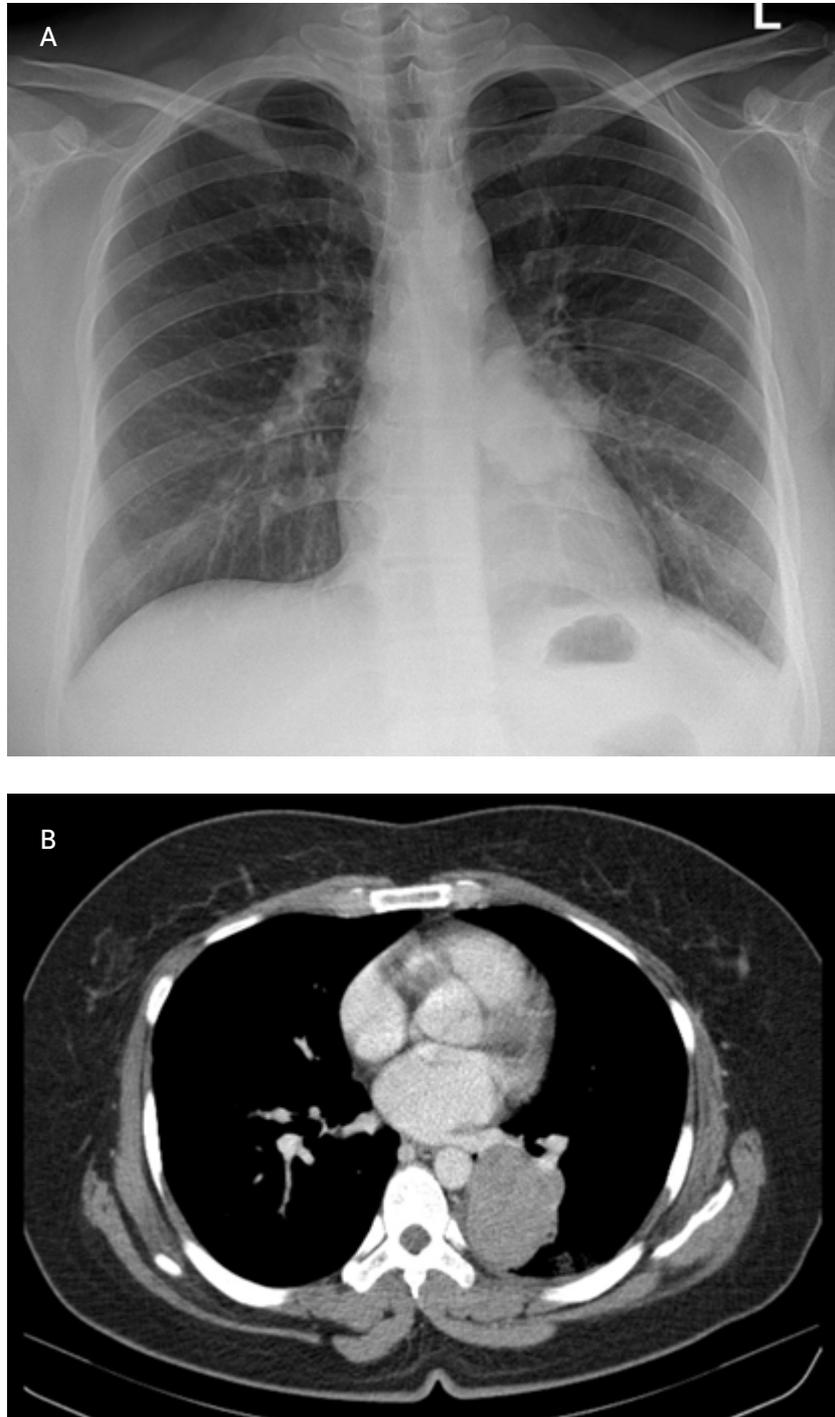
Radiological findings. (A) Chest radiograph showed a mass in the left lung. (B) Chest computed tomographic image showed a 5.5-x 4.5-cm enhancing mass in the left lower lobe.
